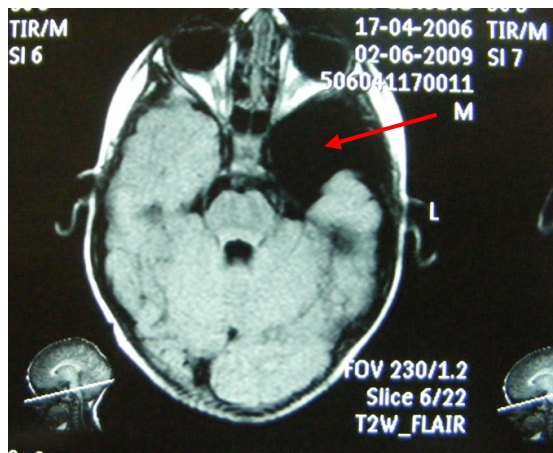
MRI preoperative aspect of a Gallasi II left temporal ACs
